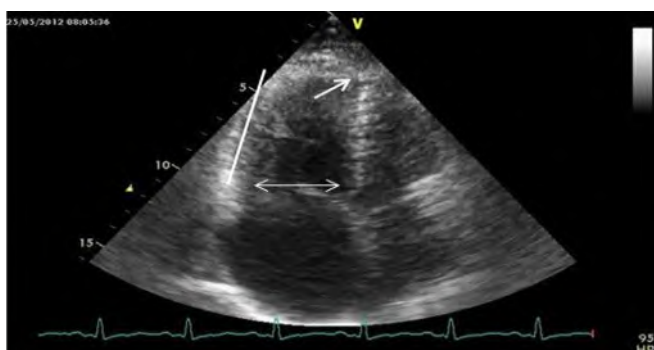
Transthoracic four-chamber echocardiography with a typical configuration is very often observed in patients with acute PE due to the decrease in the contractility of the free wall of the right ventricle and the hyperdynamic apex (McConnell's sign). The described changes are visible in real-time.
